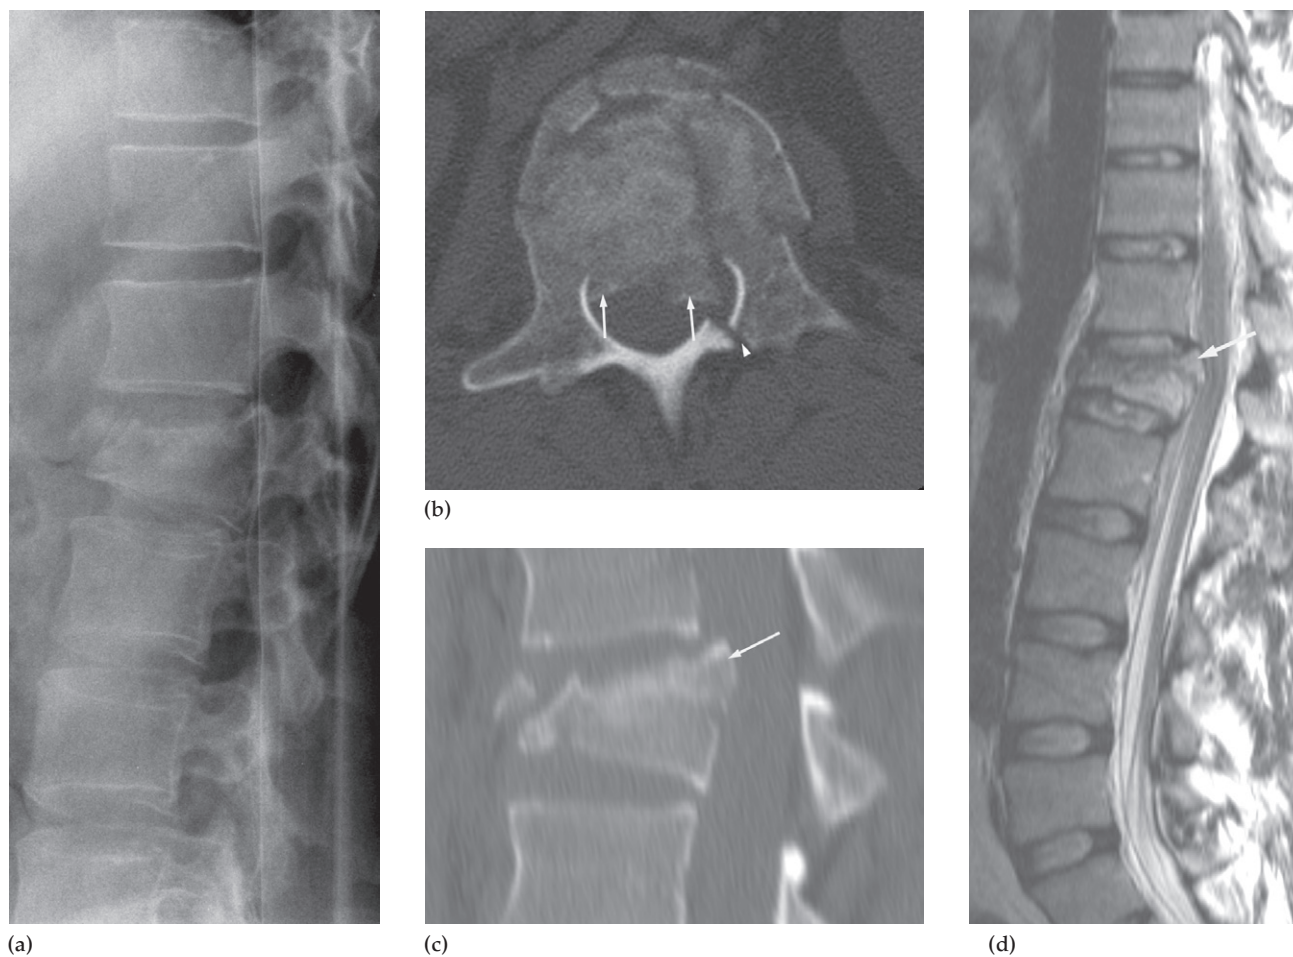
Burst fracture of L1 caused by falling 6m from a ladder. (a) Plain film showing a compression fracture of the body of L1. (b) Axial CT and (c) sagittal CT showing more clearly fragments displaced into the spinal canal (arrows). The arrowhead points to a fracture of the lamina. All three spinal columns are fractured. (d) T2-weighted MRI showing the posterior fragments causing cord compression (arrow).
